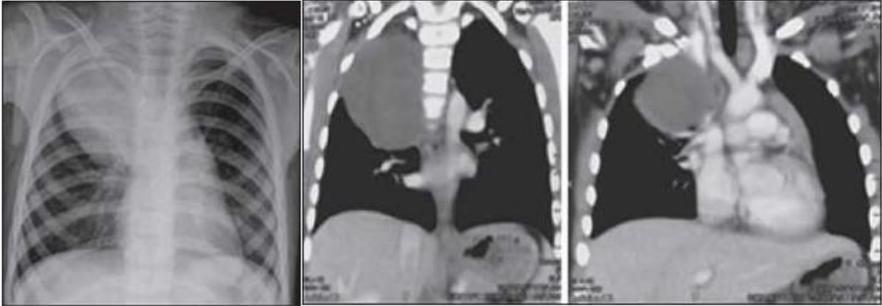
Chest X-ray, and CT and MRI of a five-year-old girl patient with a mass in the right hemithorax
